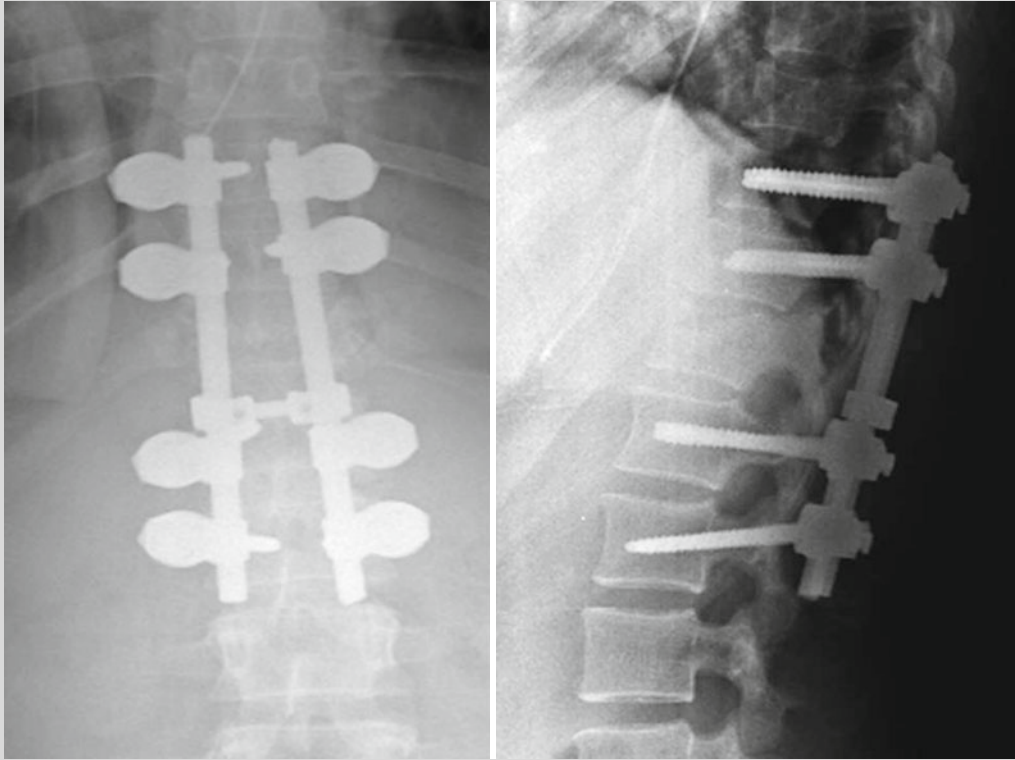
Anteroposterior and lateral radiographs in the postoperative setting following “spine-damage-control” procedure demonstrating reduction of spinal
